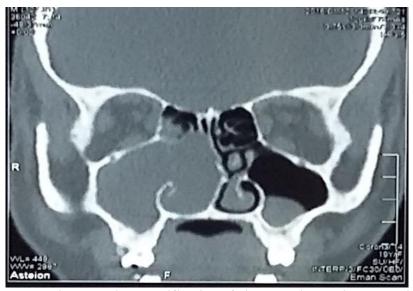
CT scan coronal view showing opacification of right maxillary sinus and right nasal cavity by Acp.+deviated nasal septum to the left+hypertrophied left inferior turbinate .(NB.no bone erosion of the right maxillary sinus)
